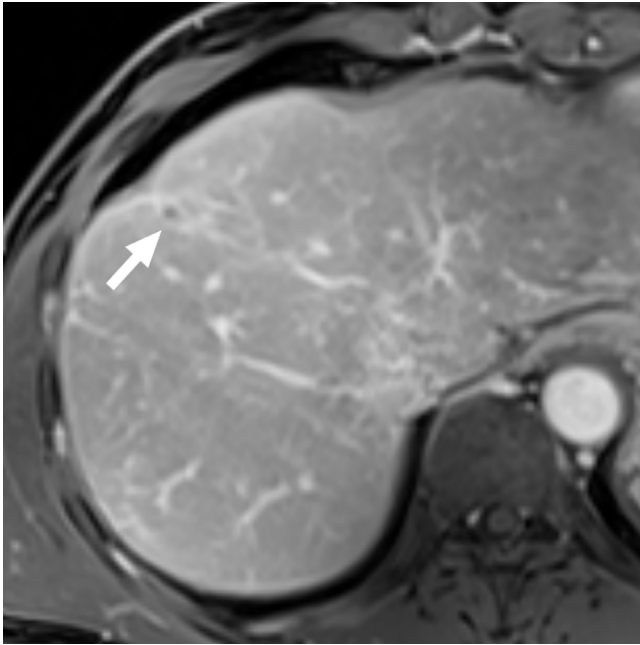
Axial MRI image after intravenous contrast obtained almost 5 years after cryoablation/immunotherapy shows a scar where a large tumor was partially treated with ablation (arrow). The liver was free of viable HCC.
